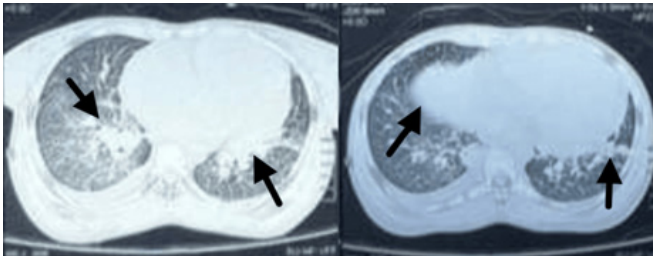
CT Chest of the patient. (Left) The arrows depict consolidation of the middle lobe of the right lung and the consolidation of the lower lobe of the left lung. (Right) The arrows depict consolidation of the both lower lobes.
